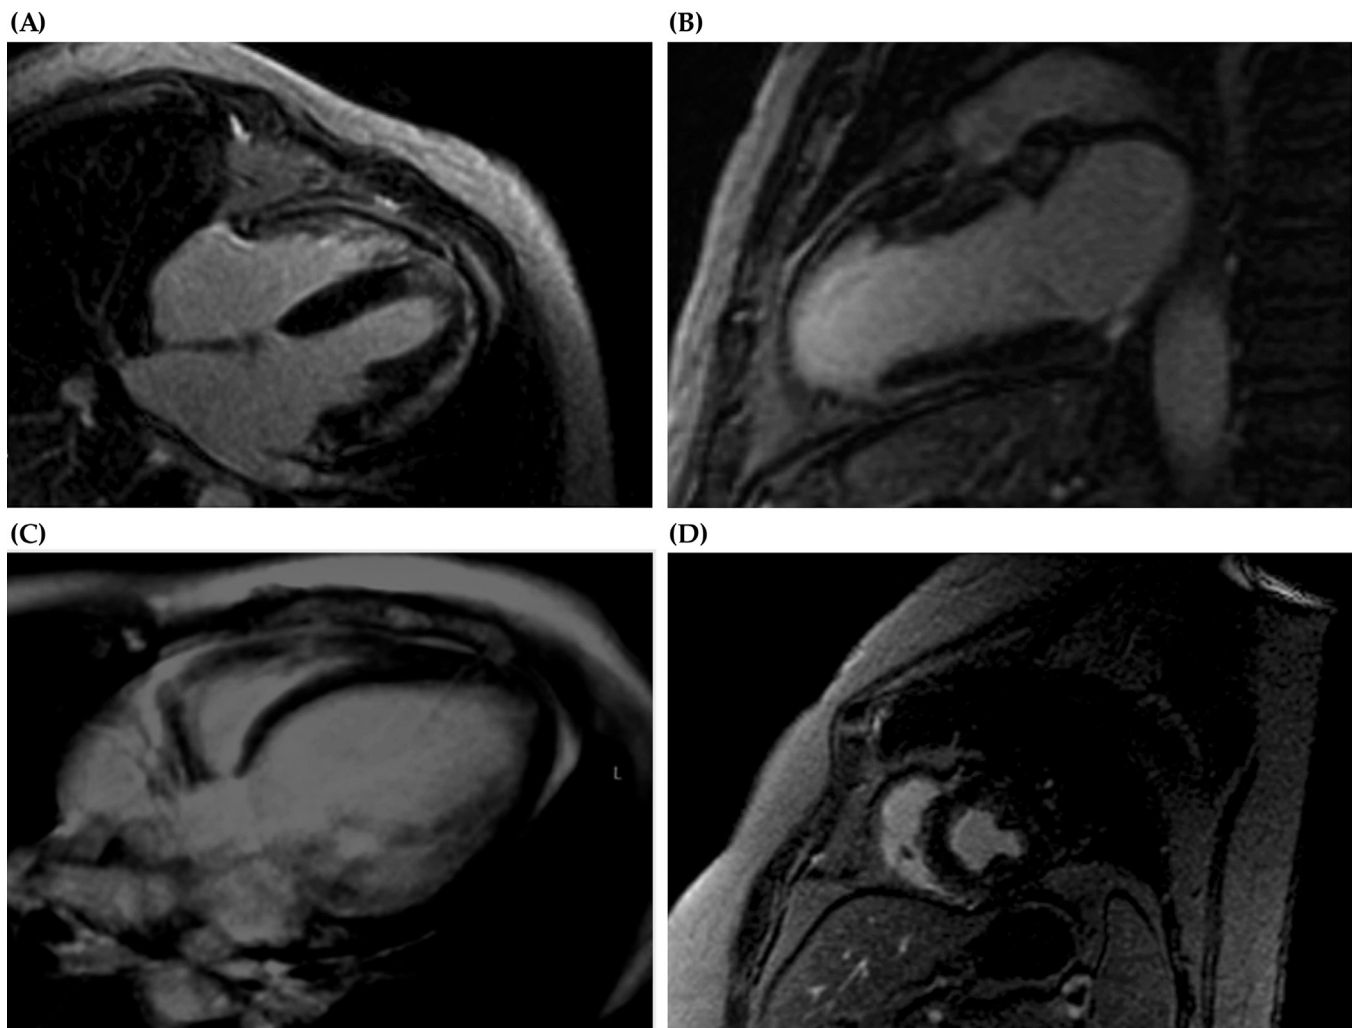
Different patterns of cardiac MRI imaging in RA. (A) Myocardial inflammation. (B) Myocardial ischemia due to MI. (C) Dilated cardiomyopathy. (D) Diffuse subendocardial fibrosis. *Adapted from Mavrogeni et al. [38].*
